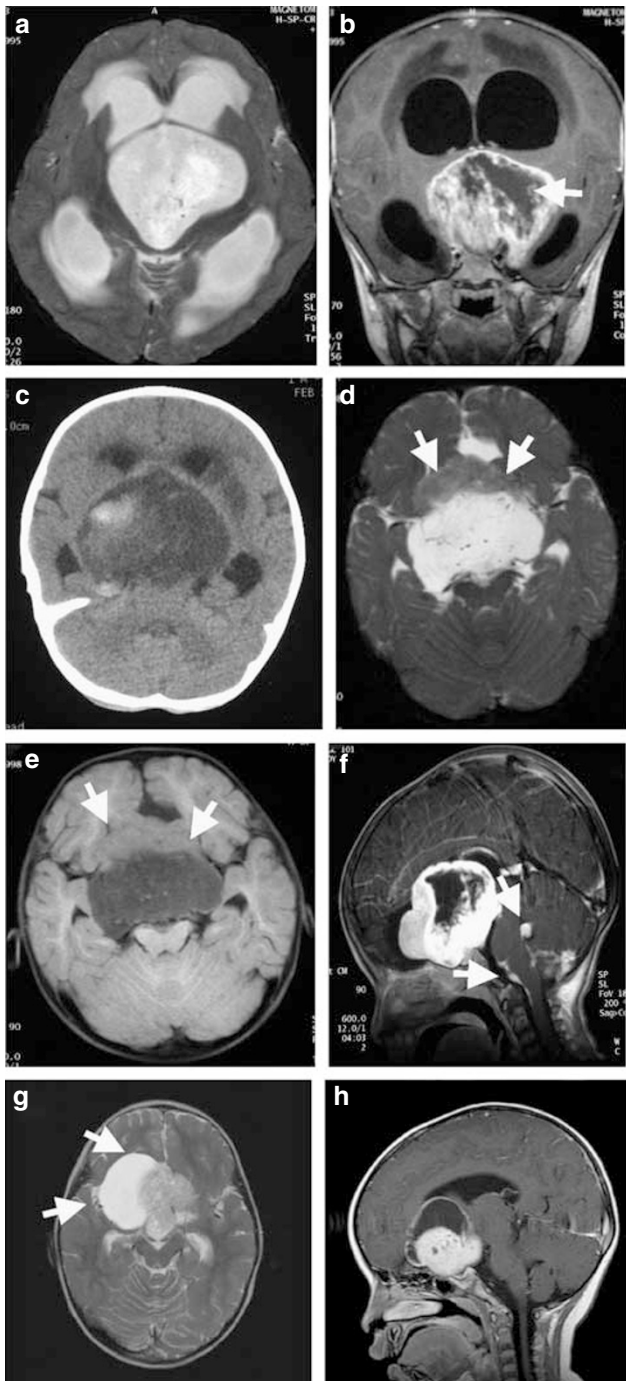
Representative radiological features of pilomyxoid astrocytoma. Patient no. P2 (a, b), Patient no. M4 (c–f), and Patient no. P6 (g, h). (a) The T2-weighted axial image shows a well-defined, heterogeneously high signal intensity mass in the suprasellar area with the hydrocephalus. (b) On the contrast-enhanced coronal T1WI, the tumor shows a heterogeneous peripheral enhancement with the central non-enhancing portion (arrow). (c) The precontrast CT scan shows a well-defined low-attenuating mass in the suprasellar area with a focal high attenuating portion suggesting hemorrhage. (d) The T2-weighted axial image shows a heterogeneous high signal intensity mass with a focal iso-signal intensity portion (arrow) in the suprasellar area. (e) On the T1WI axial image, the tumor shows a heterogeneous low signal intensity with a focal iso-signal intensity portion (arrow). (f) After contrast enhancement, the mass shows a frond-like peripheral enhancement and non-enhancing central portion. Note the nodular or linear enhancement along the 4th ventricle and cisternal space, suggesting CSF tumor seeding (arrows). (g, h) An obvious unilocular cystic portion (arrow) and bubbly microcystic lesions are visible within the solid portion.
